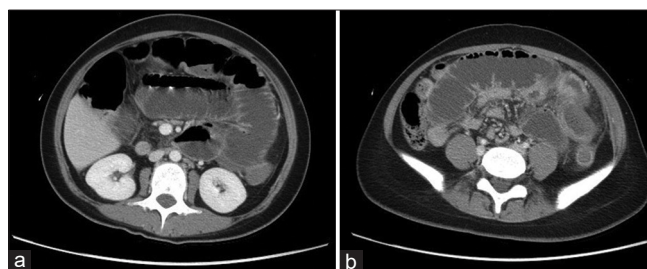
(a and b) Computed tomography of the abdomen showed distended small bowel loops and air-fluid content. The bowel wall showed edematous change but no ischemic signs such as pneumatosis
